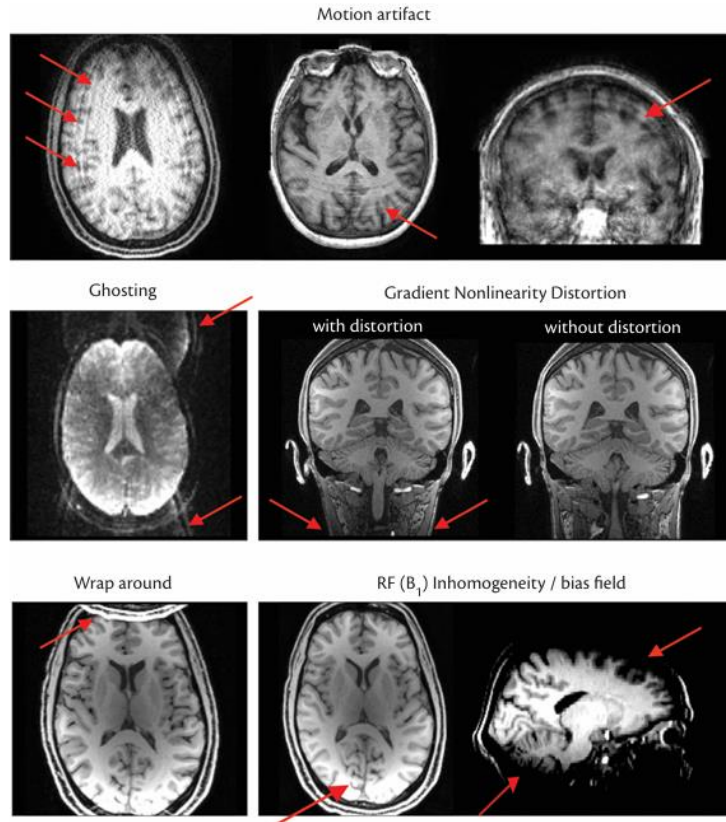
Typical artifacts from structural MRI images from [33] .
